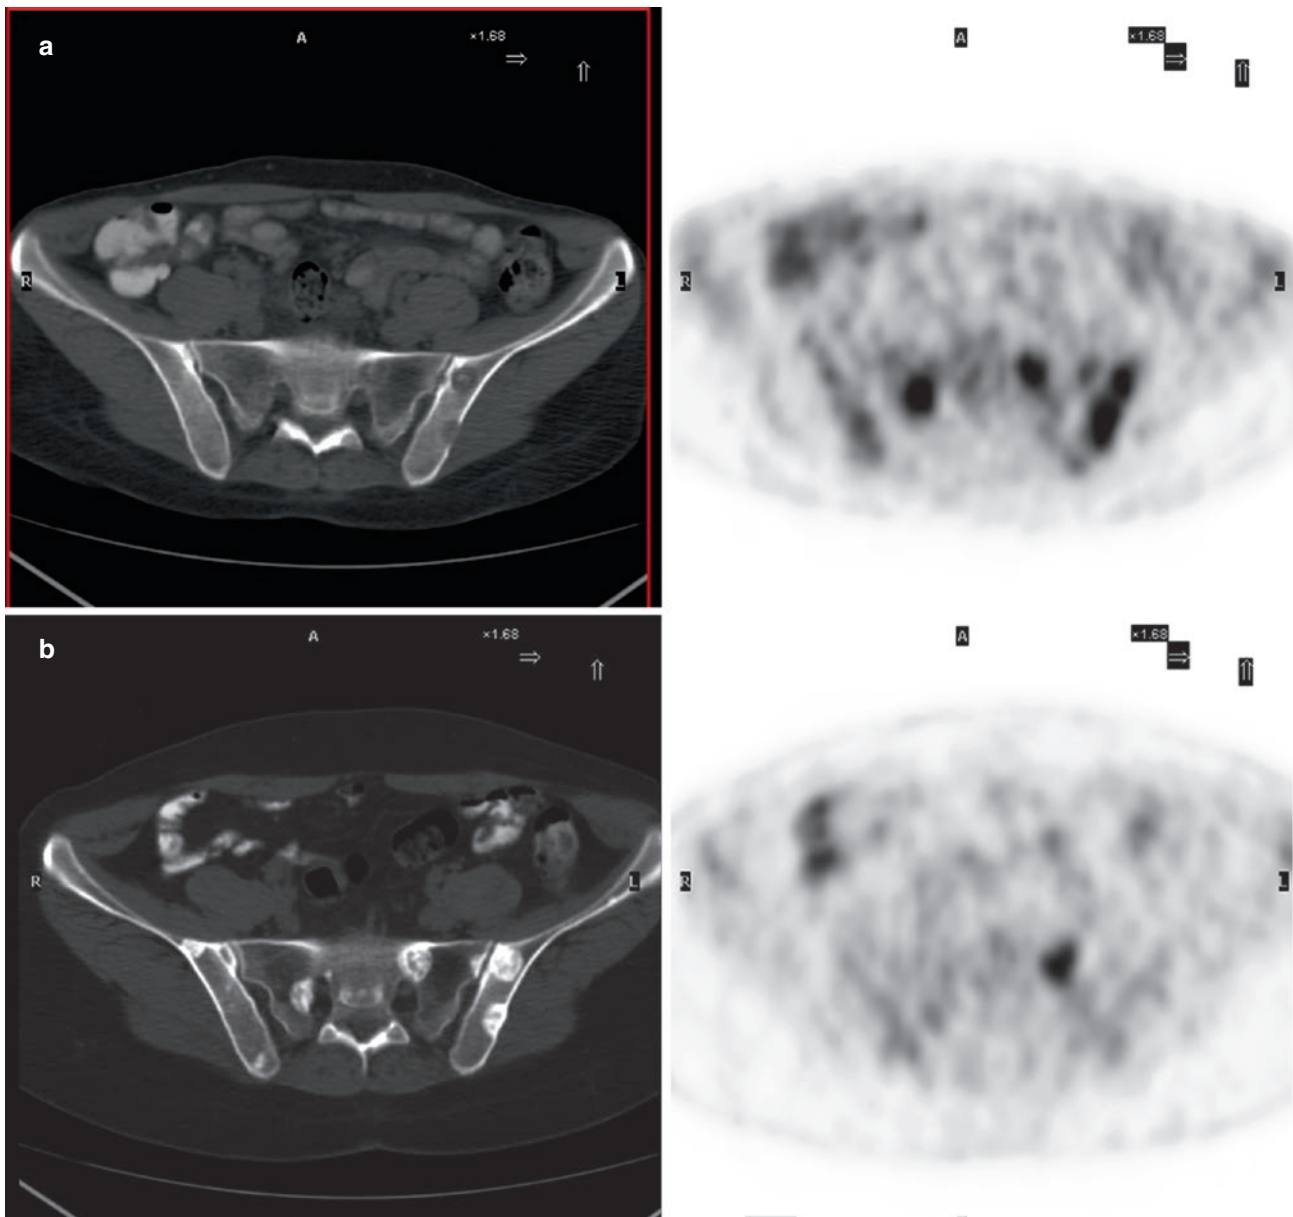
^{18}F -FDP identifying lytic and bone-marrow metastases at staging (a). After successful therapy the lesions appear sclerotic on CT with no increased uptake except for the lesion in the left sacrum which
